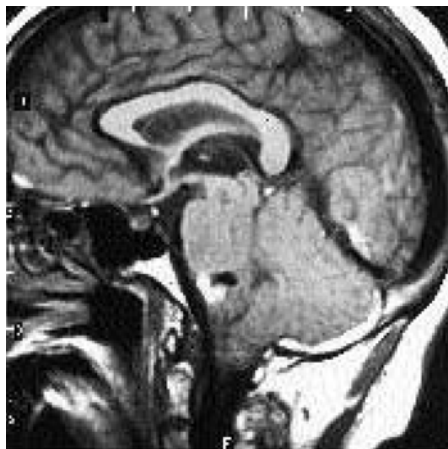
Case 5. A T_1 -weighted sagittal magnetic resonance image showing a petrosal venous aneurysm indenting the brain stem. The surrounding high-intensity signal represents subacute blood from rupture of the venous aneurysm.
